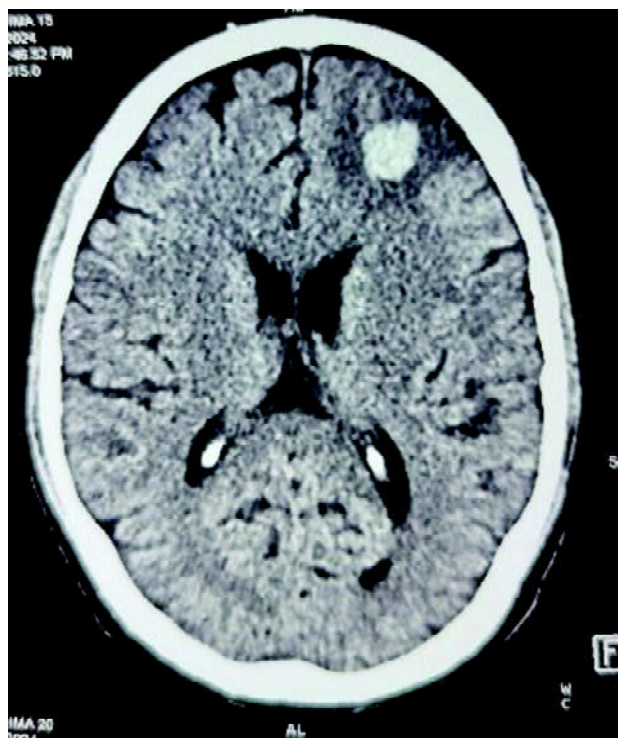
CT head showing left frontal ICH.
